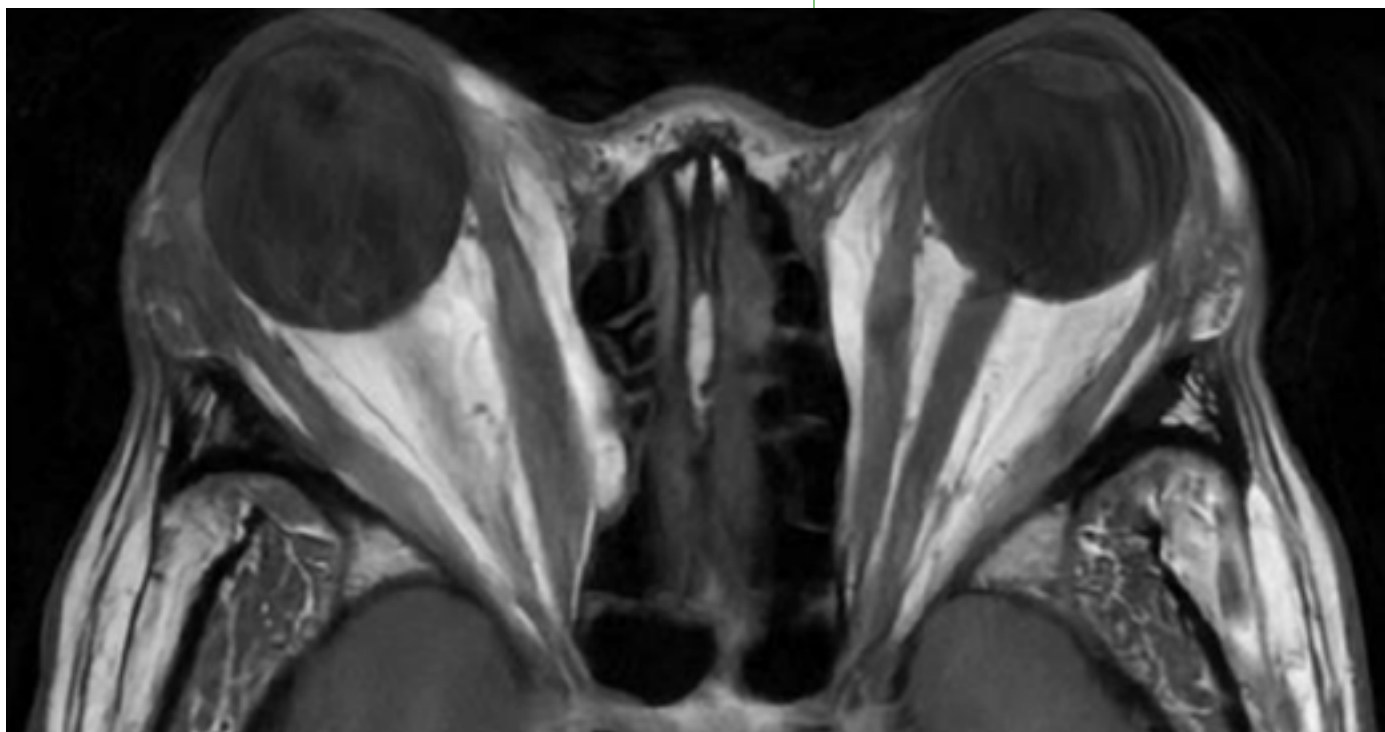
MRI scan of the orbits showing a patient with severe thyroid eye disease, manifesting as both extraocular muscle enlargement and proptosis, or bulging, of the eyes.
